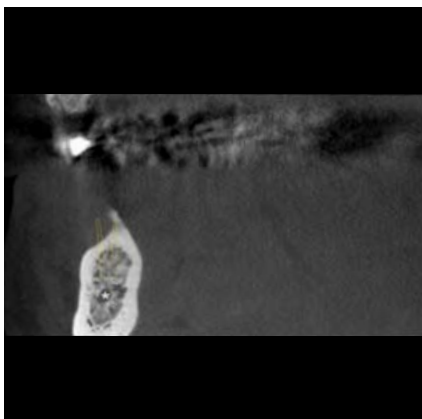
Coronal CBCT image with incisive canal (*)
